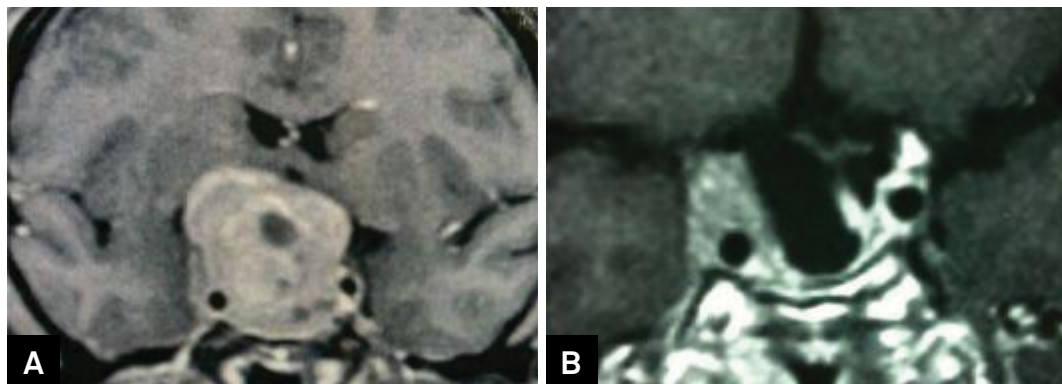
A) MRI T1 with gadolinium showing a pituitary adenoma with large suprasellar extension and invasion of the right cavernous sinus. B) Postoperative MRI demonstrating tumor remnant within the right cavernous sinus.
